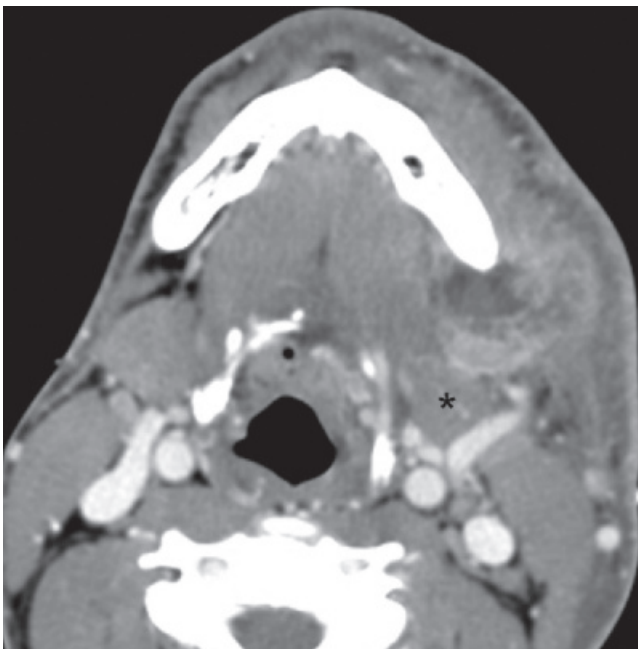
Submandibular abscess. Axial contrast-enhanced CT shows an abscess within the submandibular triangle, displacing the submandibular gland (*asterisk*) posteriorly. The abscess wraps around the inferior mandible, so it likely arose from infection in a posterior molar tooth.
